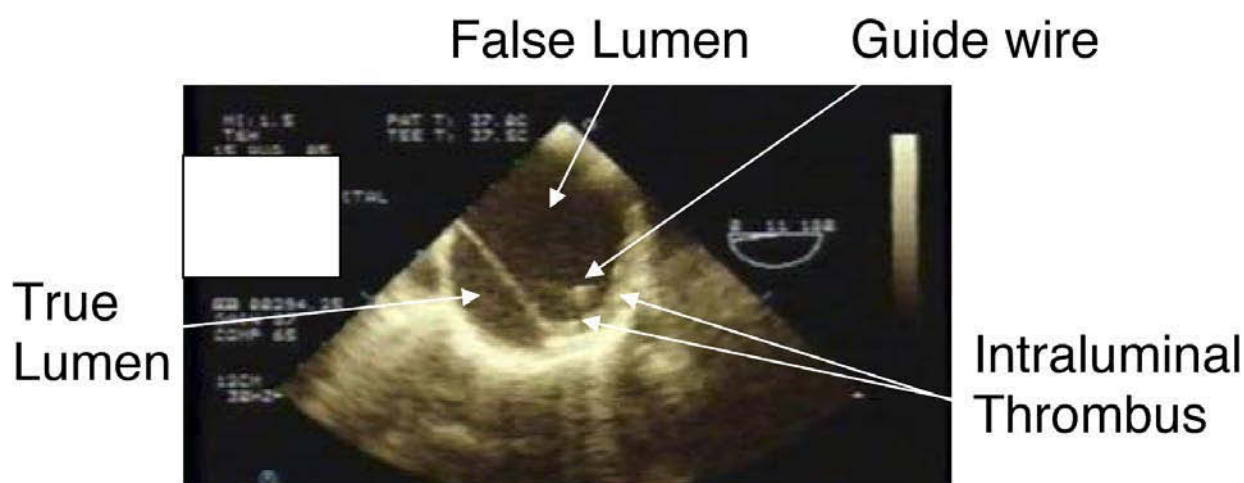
Transesophageal echocardiographic image of the descending thoracic aneurysm with flattened dissection flap. The guide wire appears in the true lumen.
